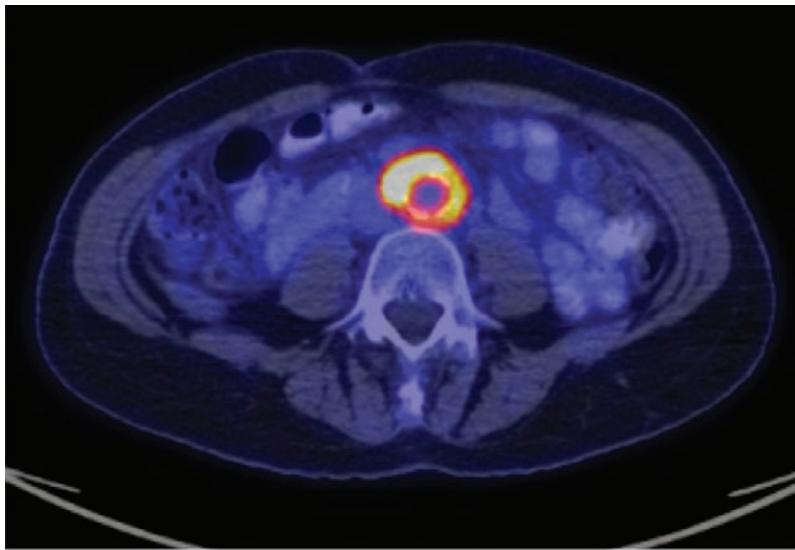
FDG PET is an accurate and straightforward test for the assessment of vasculitis. In this patient with large vessel vasculitis, intense uptake is noted involving the abdominal aorta.
